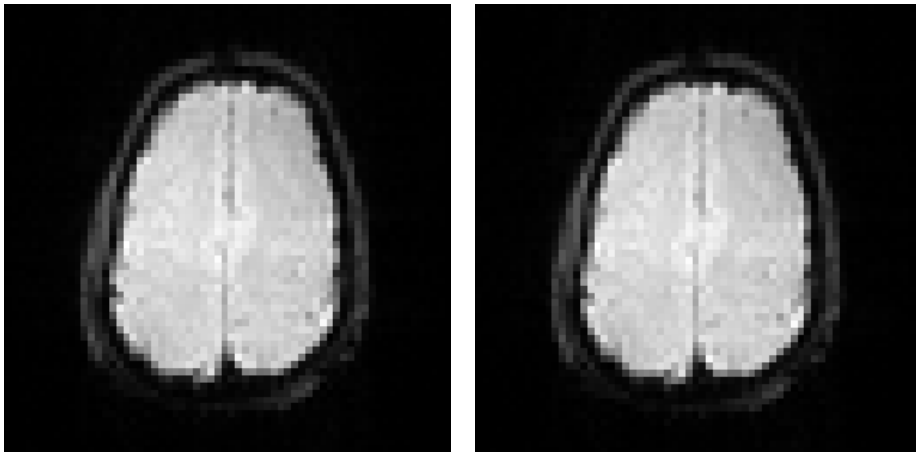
Images of a control (left) and labeled (right) acquisitions of one brain slice, acquired from a healthy subject using a PASL sequence on a 3T MRI system.
